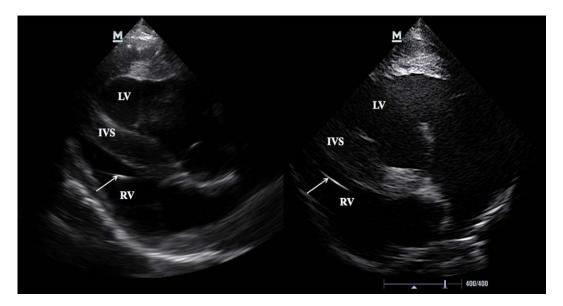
Echocardiographic image showing the electrode lead was placed in the right ventricle septum (white arrow) during systolic (left panel) and diastolic (right panel) of cardiac cycle, LV: Left ventricle, RV: Right ventricle, IVS: Inter ventricular septum
